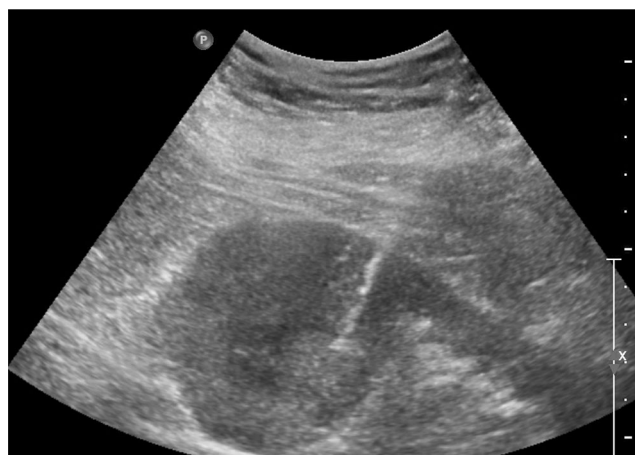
65 year old woman found to have incidental bilateral renal masses on cross sectional imaging for evaluation of a urinary tract infection. Ultrasound obtained during biopsy with the patient in anterolateral position shows introducer needle penetrating mass. Biopsy of the right renal mass revealed Fuhrman grade II clear cell renal cell carcinoma.
